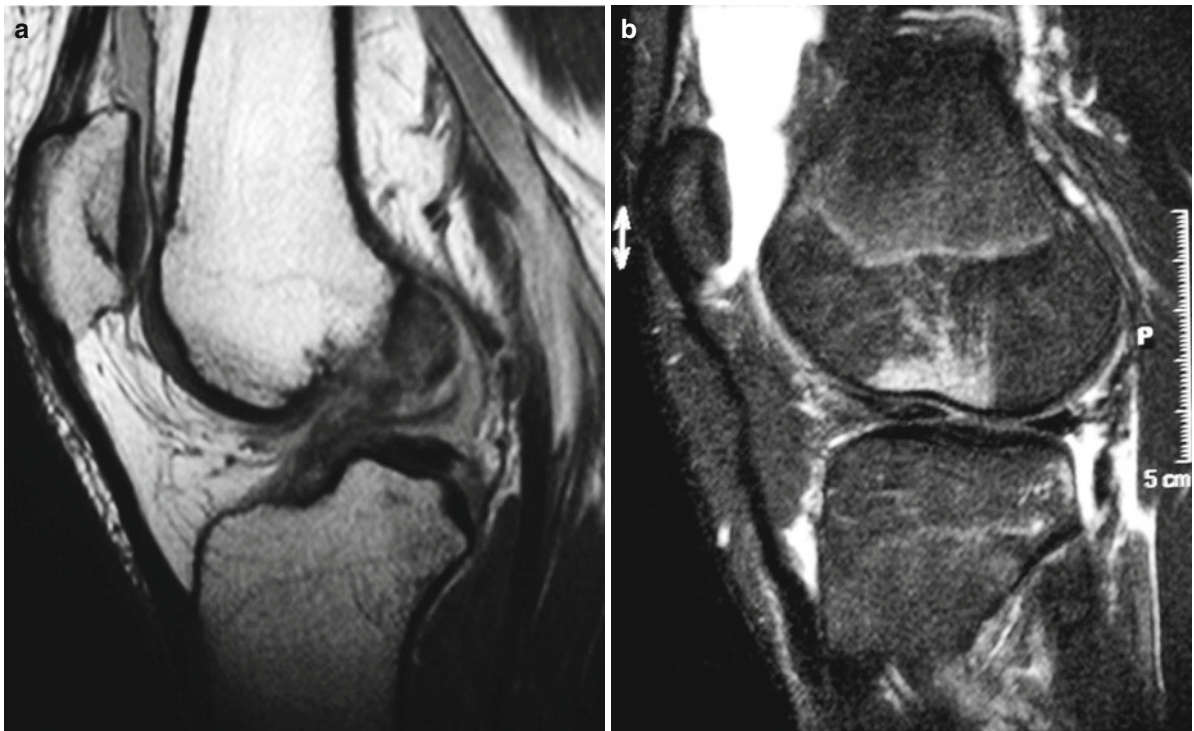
(a) MRI showing a proximal rupture of the ACL. (b) Indirect signs of an ACL rupture: Anterolateral impression fracture of the lateral femoral condyle and posterior bone bruise at the lateral tibia plateau
